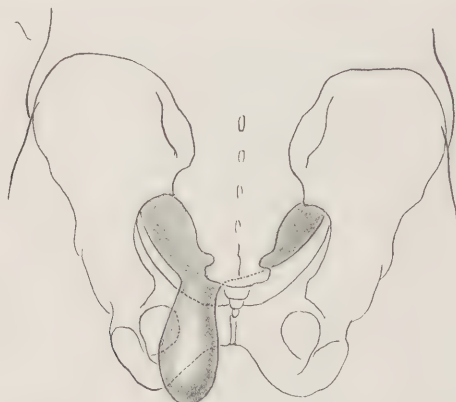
Roentgen-ray picture of sciatic hernia of a diverticulum of the sigmoid (Courtesy of Dr. Marchetti).
